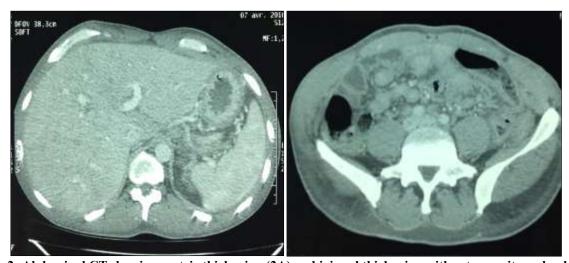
Abdominal CT showing gastric thickening (2A) and jejunal thickening with retro-peritoneal poly-ADP (2B)
